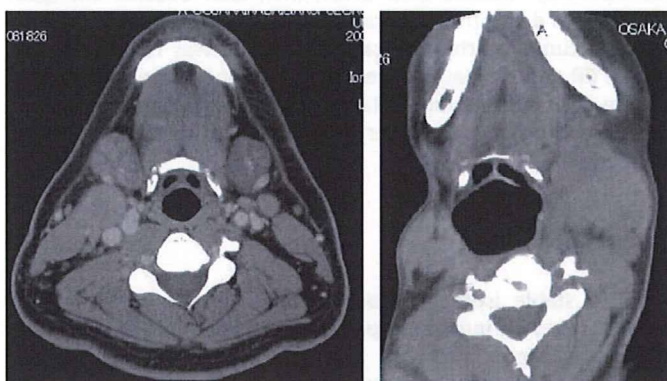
Case2: Left: CT image taken before BNCT. Right: CT image taken after BNCT. Metastasis of the lymph node reduced completely.
